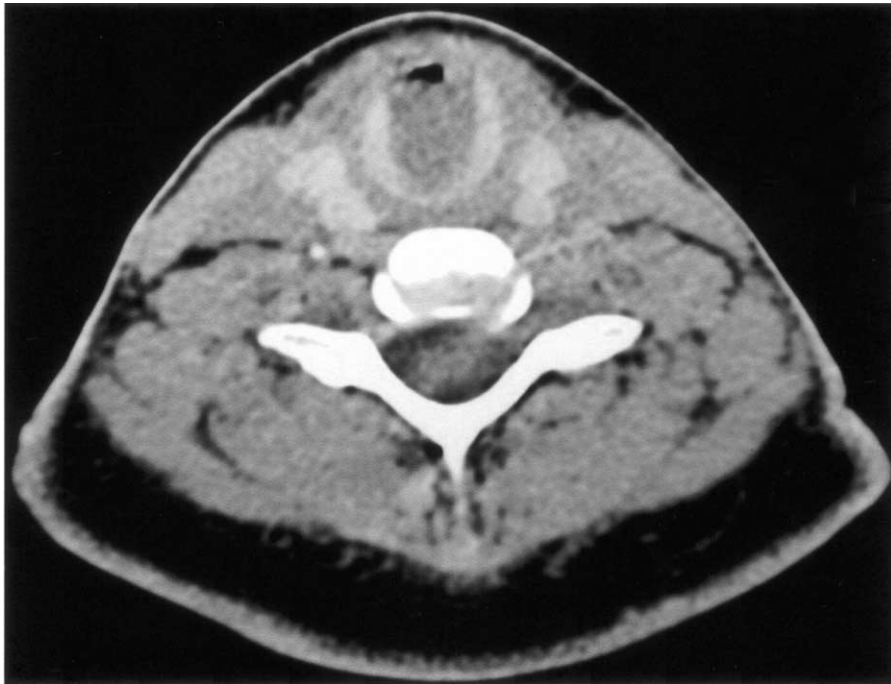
A noncontrast computed tomography scan of the chest revealed a large subglottic soft-tissue mass.
